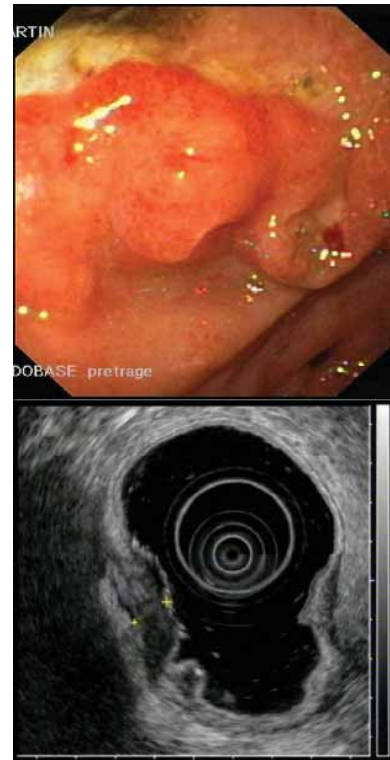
Gastric MALT lymphoma presenting as an ulcerated polypoid mass, endosonographically showing a hypoechoic lesion extending through the entire wall.
